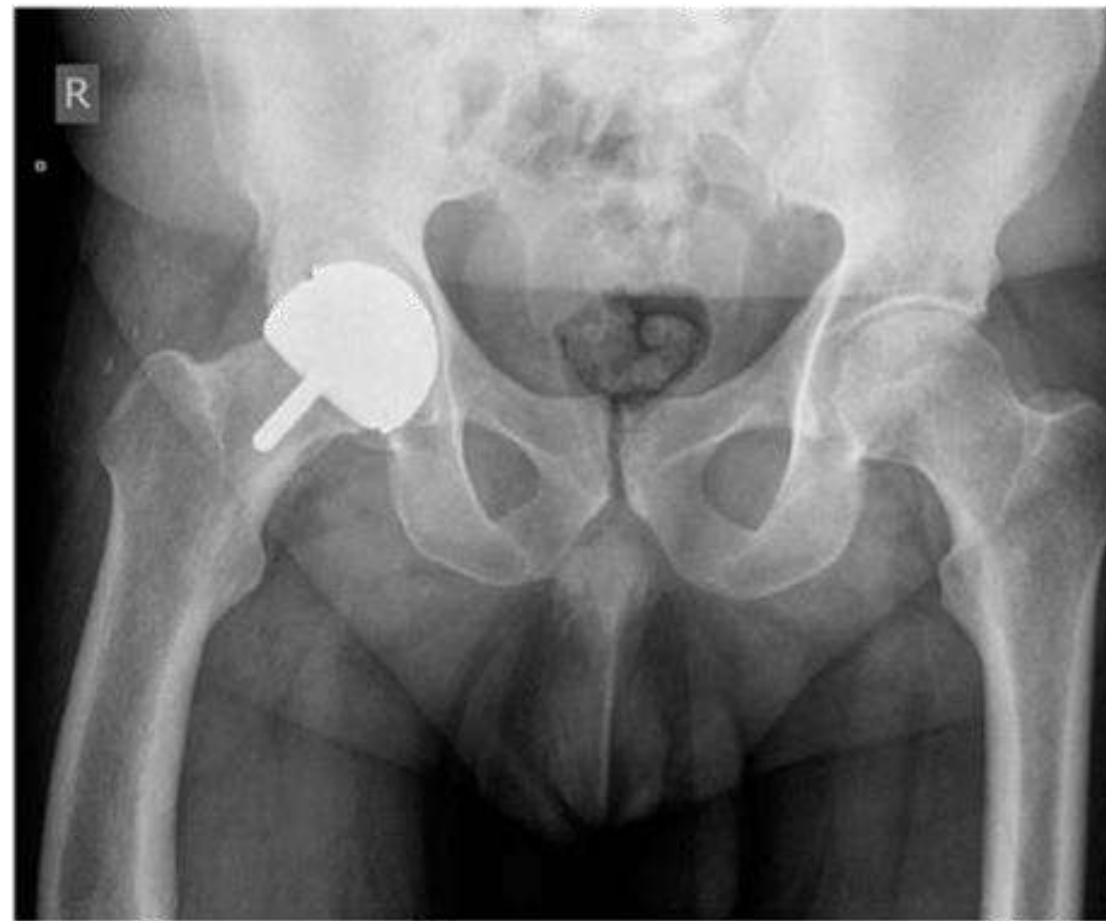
Anteroposterior (AP) radiograph right metal-on-metal hip resurfacing implant.
